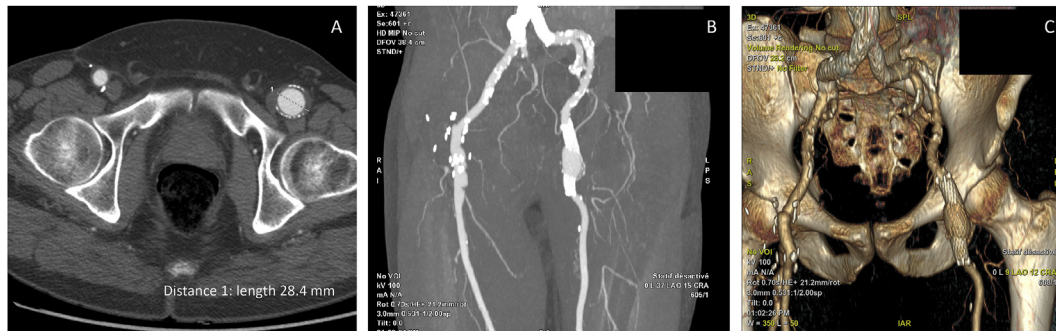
Follow up computed tomography angiography examination showing common femoral artery aneurysm (A) with possible covered stent disruption (B), as seen on three dimensions reconstructions (C).
